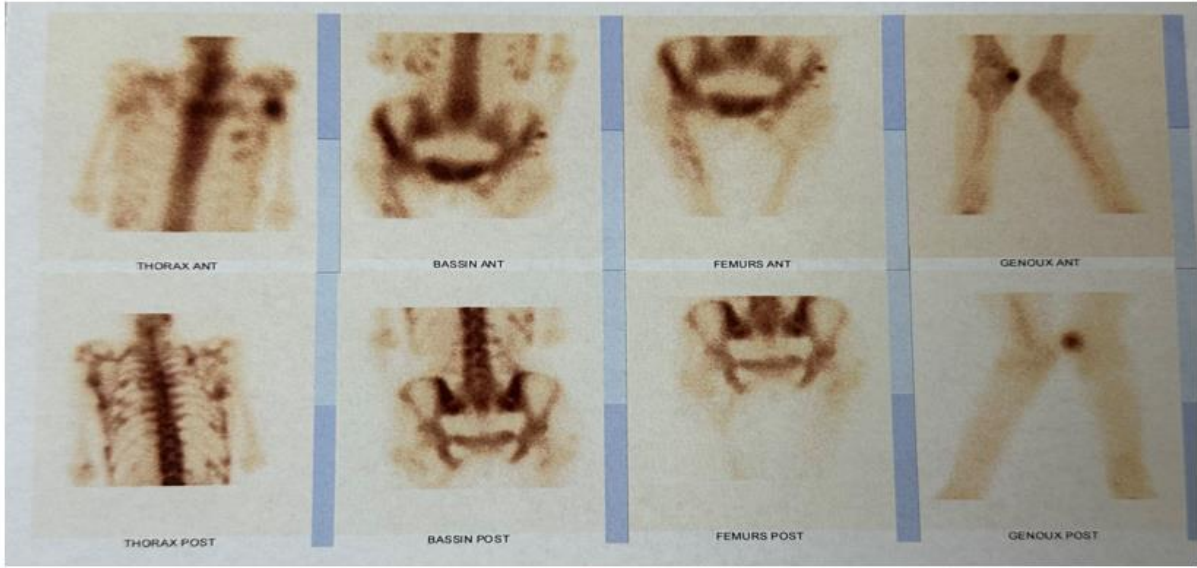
Bone scintigraphy showed several foci of hyperfixation
